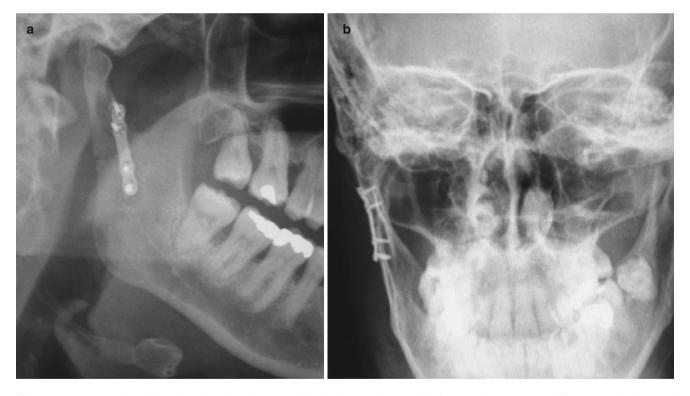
Postoperative radiographs. The plate, fracture, and occlusion are then carefully inspected to ensure good alignment, reduction, and function (a,b)
